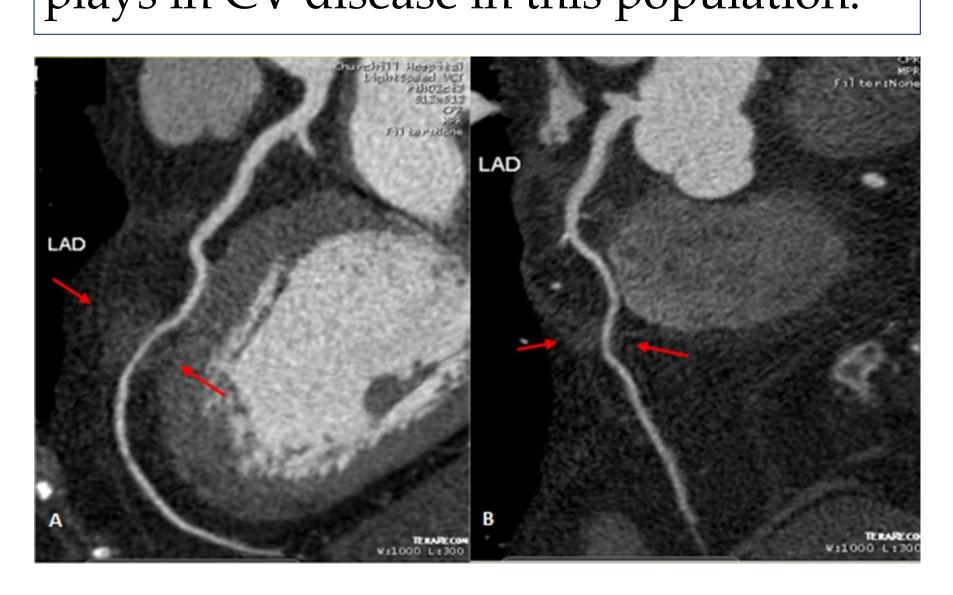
A) CT coronary angiogram imagie showing 15x15mm soft tisse mass enclosing LAD causing 25% stenosis. B) Reduction in size of the mass and relief of LAD stenosis following therapy.
